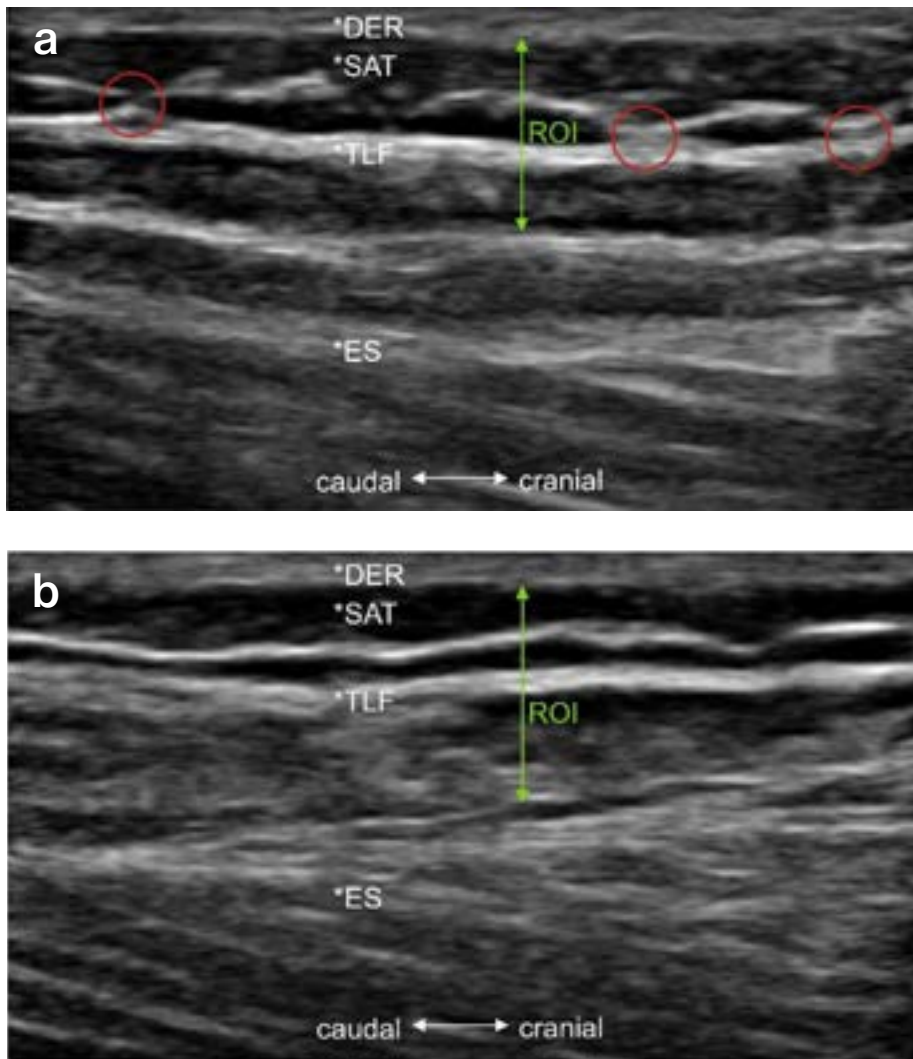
Thoracolumbar fascia of a participant from the myofascial treatment group with acute lumbar back pain. (a) Ultrasound before administering the myofascial release protocol. The circles show the adhesions between the fascial layers. Morphology rating was “somewhat disorganized” (Brandl et al. 2023, 12). (b) Ten days after the myofascial release treatment, the adhesions disappeared and the fascia was rated as “very organized” (Brandl et al. 2023, 12). [*DER indicates dermis, *SAT indicates subcutaneous adipose tissue, *TLF indicates thoracolumbar fascia, *ES indicates erector spinae muscle, and ROI is the region of interest.] Permission to publish images allowed under Creative Commons Attribution (CC BY) license.
